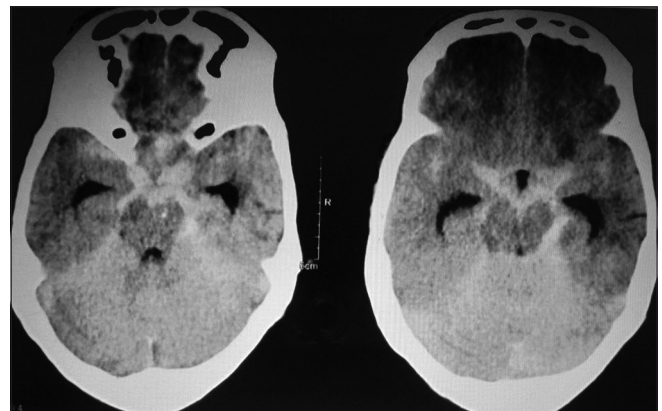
Computed tomography scan showing subarachnoid haemorrhage involving perimesencephalic cisterns, sylvian cistern and tentorium
